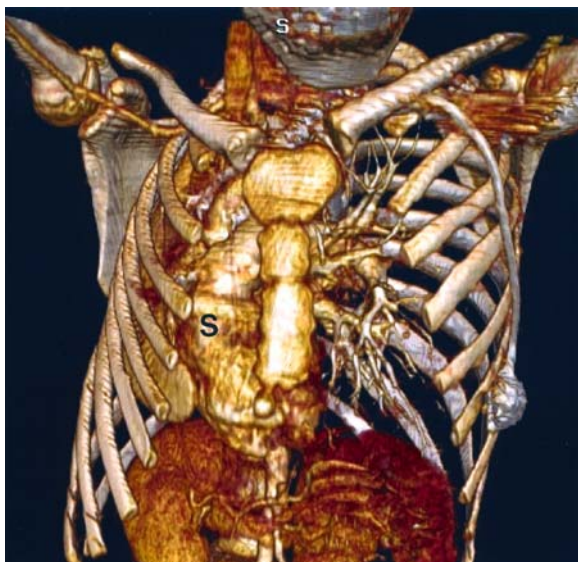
Chest wall deformity secondary to prior pneumonectomy. A pre-operative CT scan was done to assess the volume of the right hemithorax prior to insertion of a chest prosthesis. Coronal volume rendered image shows a small right hemithorax and dextroscoliosis of the thoracic spine (S)
